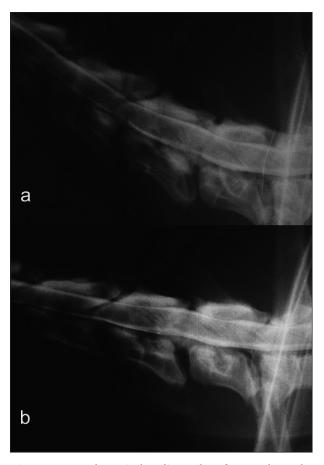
Lateral cervical radiographs after myelography in neutral position (a) and during traction (b). Note that hourglass compression C5/6 disappeared during the traction.
